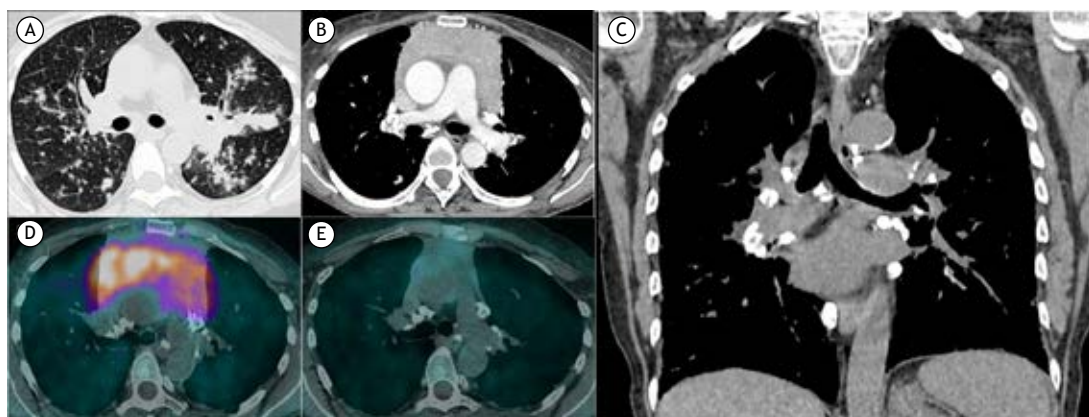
In A, an axial CT image of the chest (lung window) showing small nodules with peribronchovascular infiltrations. Mediastinal lymph node enlargement was also observed (not shown). In B, axial CT image (mediastinal window) showing a large mass with soft-tissue density in the anterior mediastinum. In C, a coronal reconstruction image (mediastinal window) showing the mediastinal mass and lymph node calcifications in multiple hilar and mediastinal chains. In D, axial PET/CT fusion image showing diffusely high ¹⁸F-fluorodeoxyglucose (¹⁸F-FDG) uptake of the mass. In E, PET/CT image acquired 10 months after treatment initiation showing marked reduction of the mass volume and absence of ¹⁸F-FDG uptake. Note also mediastinal lymph node calcifications.
